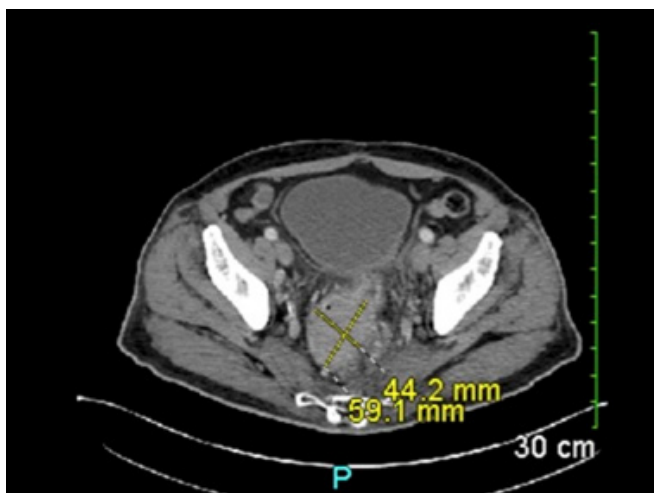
Abdomen/pelvis CT showing the rectal mass measuring 44.2 x 59.1 mm.
